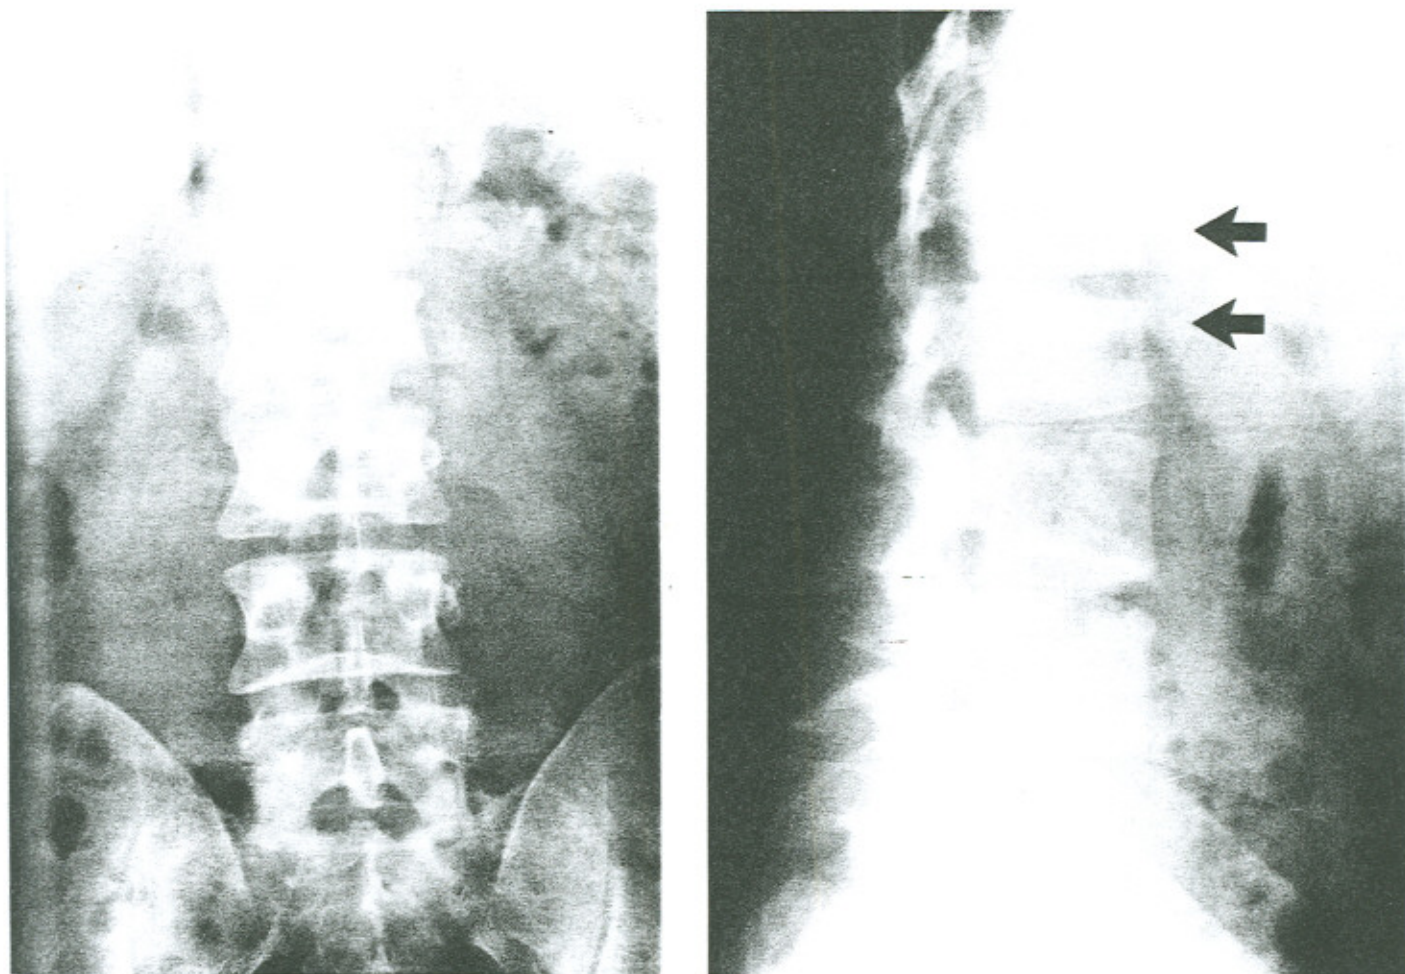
AP and lateral radiographs of case 2, reported as normal. Slight compression of both L1 and L2 is noted with radiodense lines along the fracture sites (arrows).
